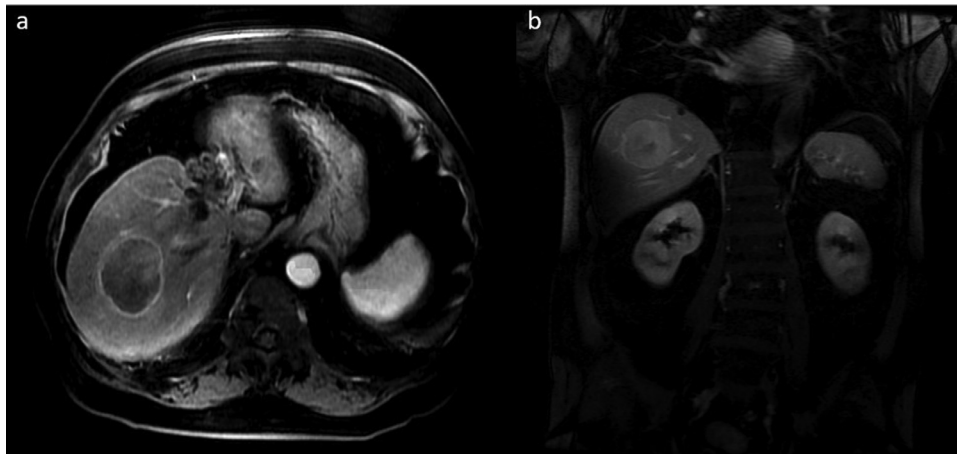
(a and b). A contrast-enhanced MRI scan of the body was obtained. T1-weighted axial (a) and coronal (b) views showed a 5.5-centimeter nonenhancing mass in hepatic segment 7/8 with 2 smaller lesions superiorly; these were highly suspicious for a malignant neoplasm
